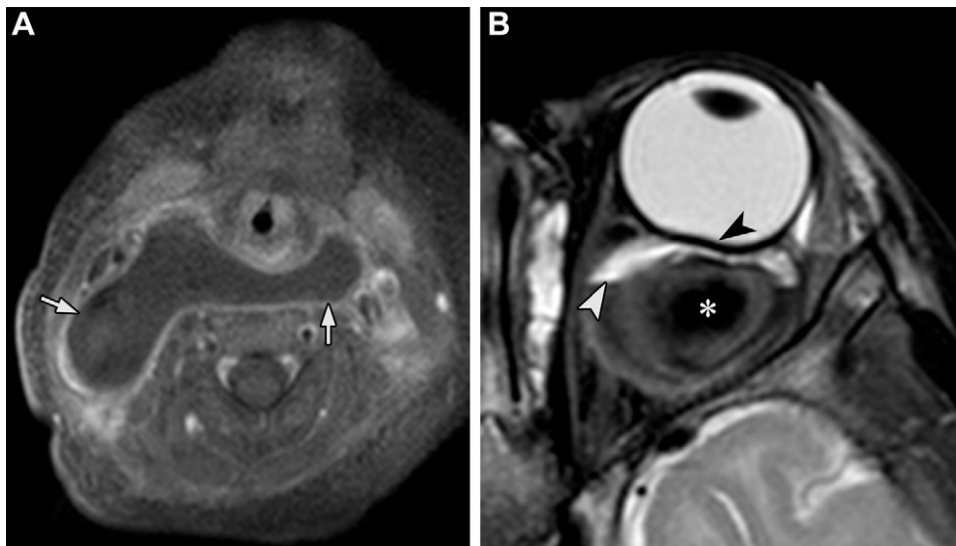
Complicated lymphatic malformations (LMs) in two pediatric patients. (A) Axial contrast-enhanced T1W FS MR image in a 14-month-old boy with a known LM and fever shows a large retropharyngeal LM with a thick rind of enhancement and surrounding cellulitis (arrows). (B) Axial T2W FS MR image in a 6-month-old boy with proptosis shows acute hemorrhage (*) within an intraorbital LM. Note the fluid-hemorrhage level (white arrowhead) and marked flattening of the posterior globe (black arrowhead).
